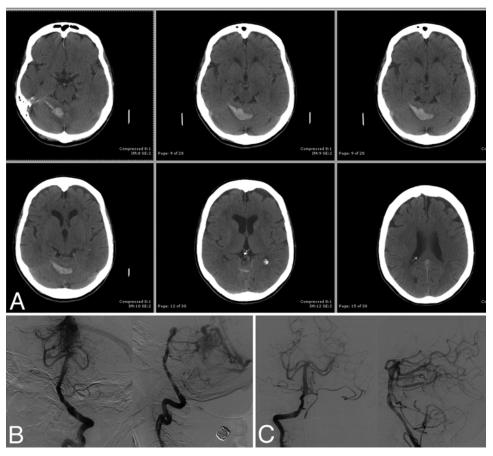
Images obtained in a 77-year-old woman with a medical history significant for hypertension, heart murmur, and Crohn disease requiring large doses of aspirin. She awoke with headache, dizziness, and incoordination of the right arm. A: Unenhanced axial CT scans of her brain reveal acute hemorrhage of the right cerebellum extending to the tentorial surface and across the vermis to the left hemisphere. B: Although she had multiple risk factors for spontaneous intracerebral hemorrhage (such as hypertension, possible cardiac embolism related to the cause of her heart murmur, aspirin use, and possible age-related amyloid angiopathy), the unusual location of the hemorrhage and questionable prominence of vessels near the vein of Galen prompted further imaging. This frontal view of a left vertebral catheter angiogram reveals an AVM of the cerebellar vermis supplied primarily by branches of the bilateral superior cerebellar arteries. High risk features include feeding artery aneurysms bilaterally and venous outflow restriction of the draining vein coursing to the straight sinus. C: The patient underwent a series of staged liquid adhesive embolization sessions to protect against rehemorrhage. This frontal view of left vertebral catheter angiography after embolization reveals elimination of the feeding artery aneurysms and significantly reduced flow through the nidus.
